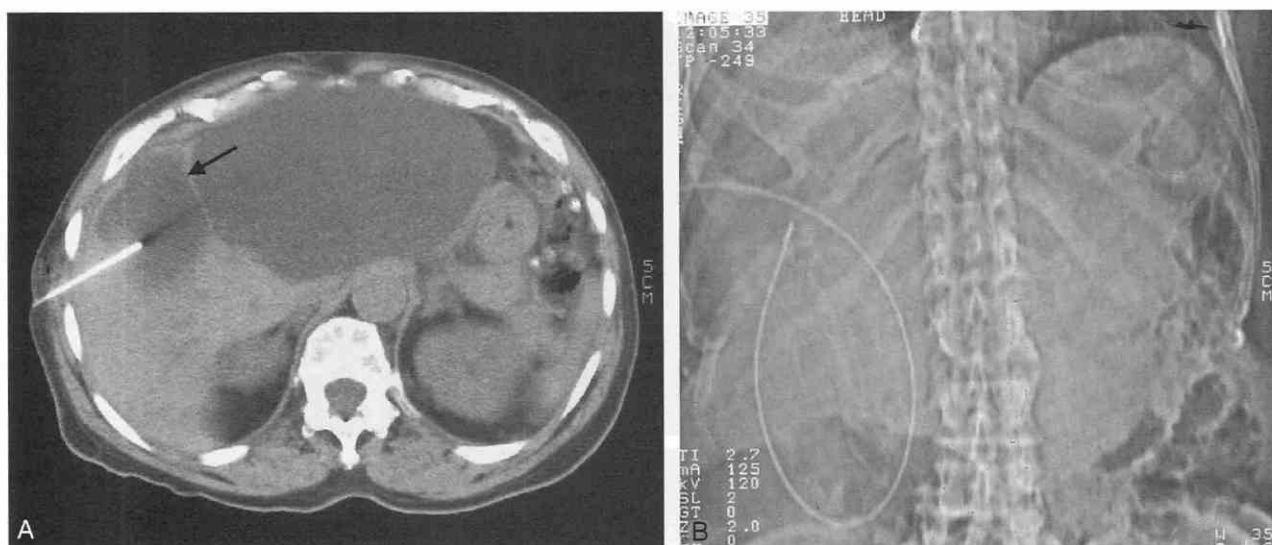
A, Scan shows two large cysts that are separated by a septum (arrow). The needle was inserted to permit puncture of both cysts. Note that the path was chosen to provide a cuff of normal liver to prevent the spillage of either cyst fluid and alcohol when it is injected at a later time. B, Radiograph shows the insertion of wire and catheter into the cyst cavity. The cyst is left to drain for several hours before the instillation of alcohol (see text).
